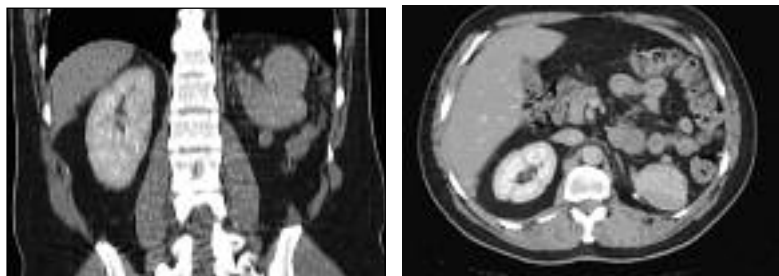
CT reveals multiple round nodules in left paracolic space
